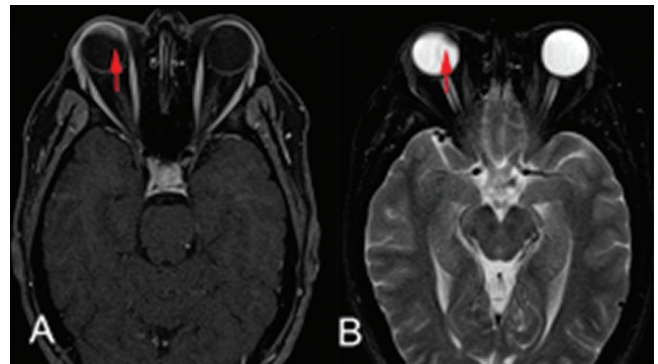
Post-contrast (A) T1-weighted magnetic resonance imaging with fat suppression and gadolinium enhancement, and (B) T2-weighted magnetic resonance imaging of brain and orbits showing an intraocular mass in the right eye, as indicated by arrow.
